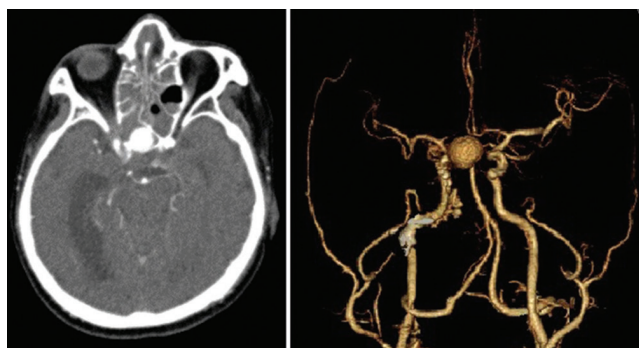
Computed tomography showing an internal artery aneurysm in the sphenoid sinus.
